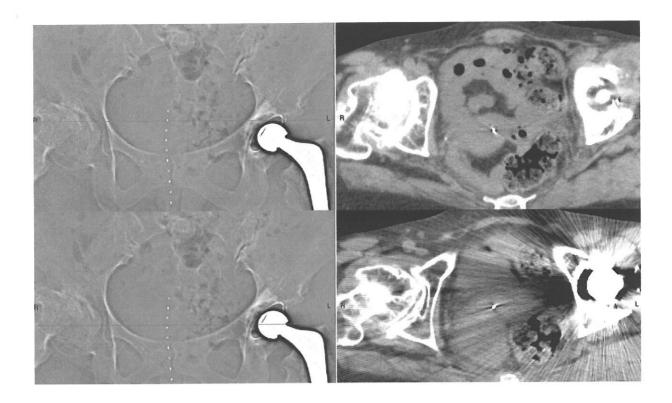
Two axial CT slices at the levels demonstrated with a green line on the topographic scan. Making determination of the tumor volume, anterior rectal wall, and posterior bladder wall is difficult on CT especially in the cases of patients with one or both side hip prosthesis. The Tungsten marker in the intracervical applicator is well represented.
